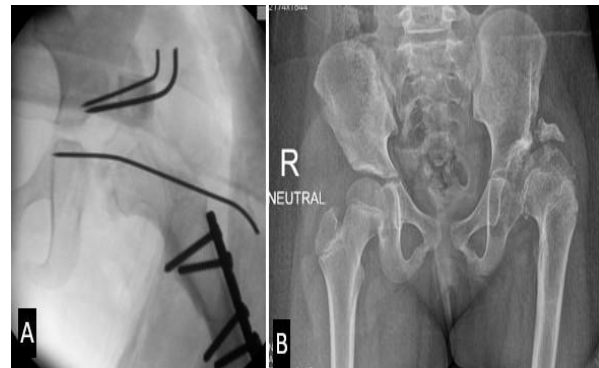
(A) Left hip fluoroscopic image after hip spica application. The femoral head and the acetabular shelf were stabilised with K-wires. The femur was fixed with a 4-hole plate after shortening; (B) Pelvic radiograph six years postoperatively. The left hip had developed coxa magna
